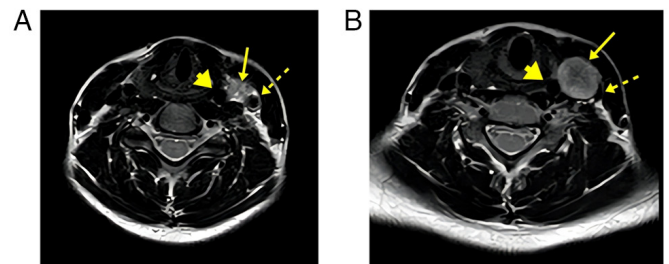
(A and B) Axial non-contrast MRI images demonstrating a well-defined, rounded mass lesion with intermediate to high T2 signal (arrow). The lesion is located anterior to the left common carotid artery (dotted arrow), below the level of its bifurcation, causing splaying of the common carotid artery (dotted arrow) and the internal jugular vein (arrow-head). It measures 20x17 mm in axial dimension.
